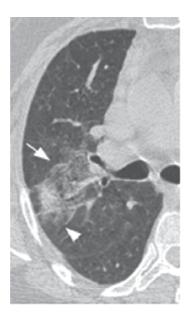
A 54-year-old female with sarcoidosis. CT of the chest shows an area of patchy groundglass opacity (arrow) in the right upper lobe. A confluent opacity (arrowhead) lateral to this area is also identified.
